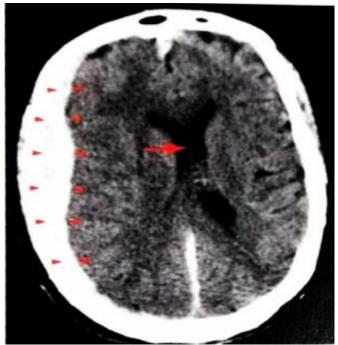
CT scan shows features of acute subdural hematoma.
